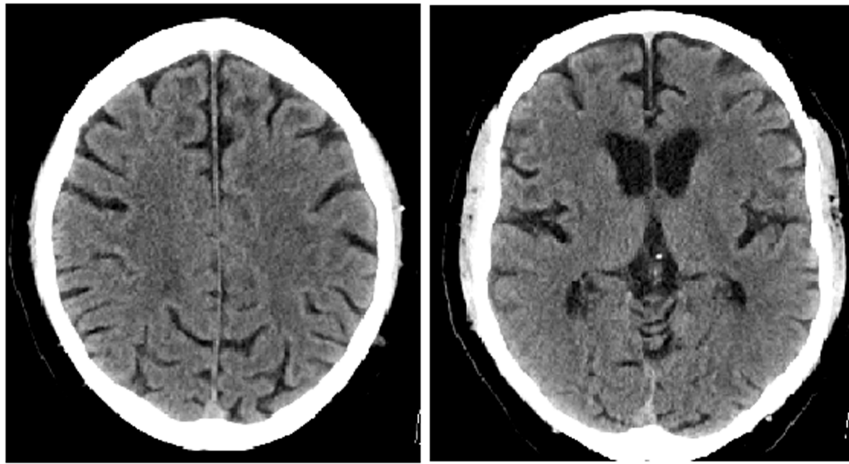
Example of ASPECTS 10 on NCCT
